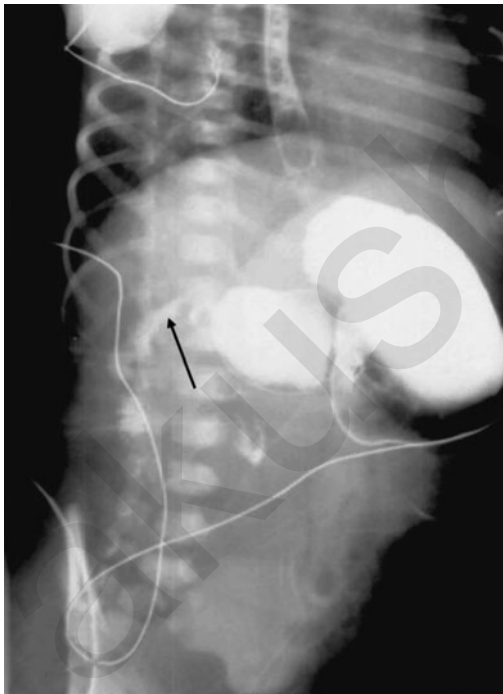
An oblique abdominal x-ray contrast study showing marked distention of duodenum terminating abruptly with narrow caliber distally (arrow). A perforated diaphragm was found at operation. Annular pancreas and malrotation were also found in this patient.
